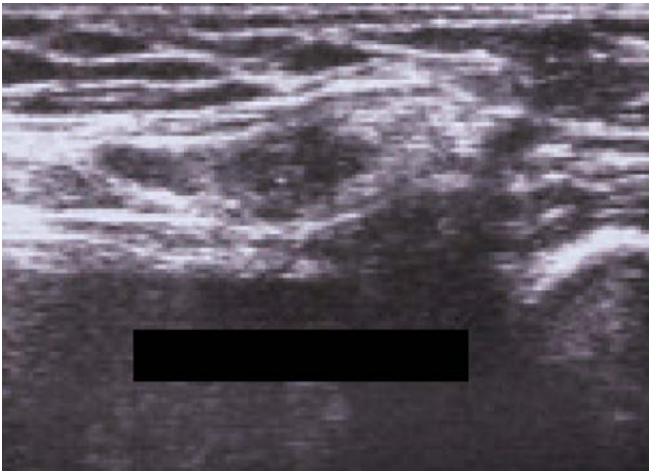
Ultrasonography: hernia sac with an unusual hypoechogenicic ultrasound structure in its background
